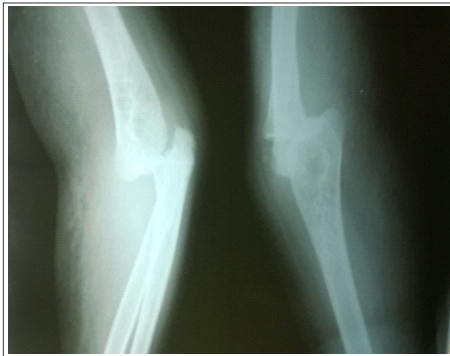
Pre-reduction X-ray of right elbow showing posterior dislocation without accompanying fracture
